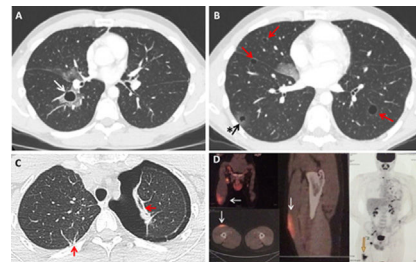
Chest computed tomography. A) Lung cyst measuring 16 mm in diameter with thin smooth walls, showing a ground glass halo in the right lower lobe (arrow). B) Multiple lung cysts with bilateral distribution (arrows), one with a ground glass halo (arrow with asterisk). C) Left pneumothorax and fibrous tracts in the vertices (arrow). D) Flat hypermetabolic lesion measuring 4 × 1.9 cm (SUV 5.3) in the right vastus lateralis muscle (arrows), associated with hypermetabolic inguinal lymphadenopathies in the same side.
